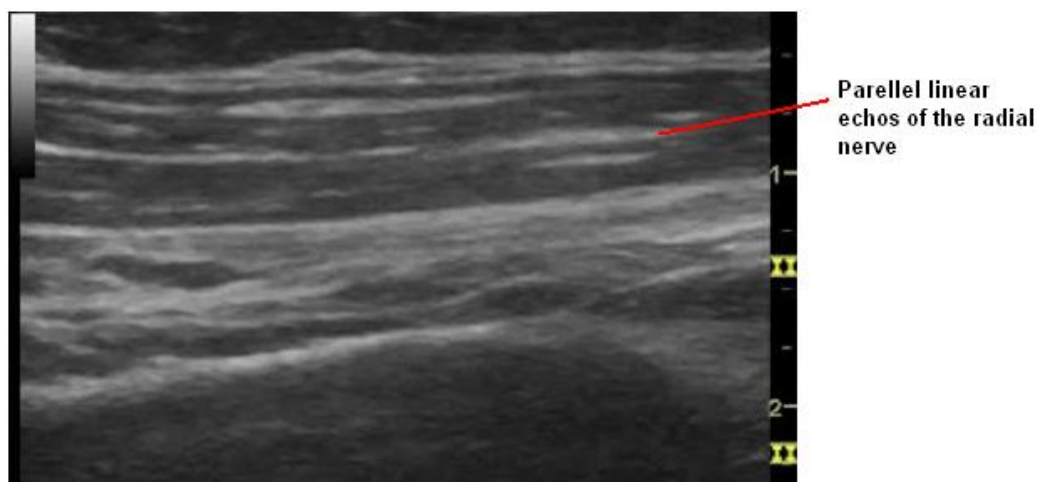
Longitudinal sonogram of the radial nerve.
